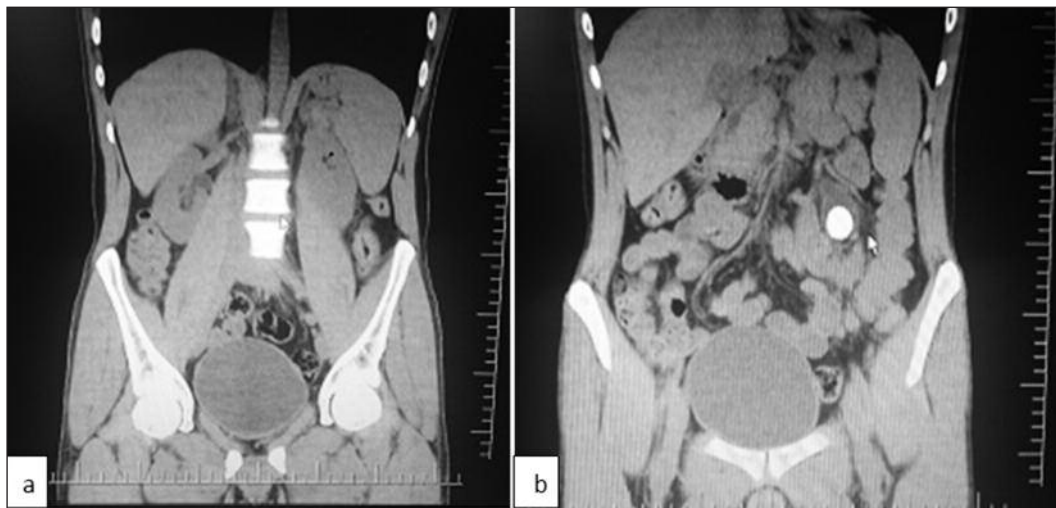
CT scans without contrast a) bilateral normal kidney; b) left supernumerary kidney with stone.
